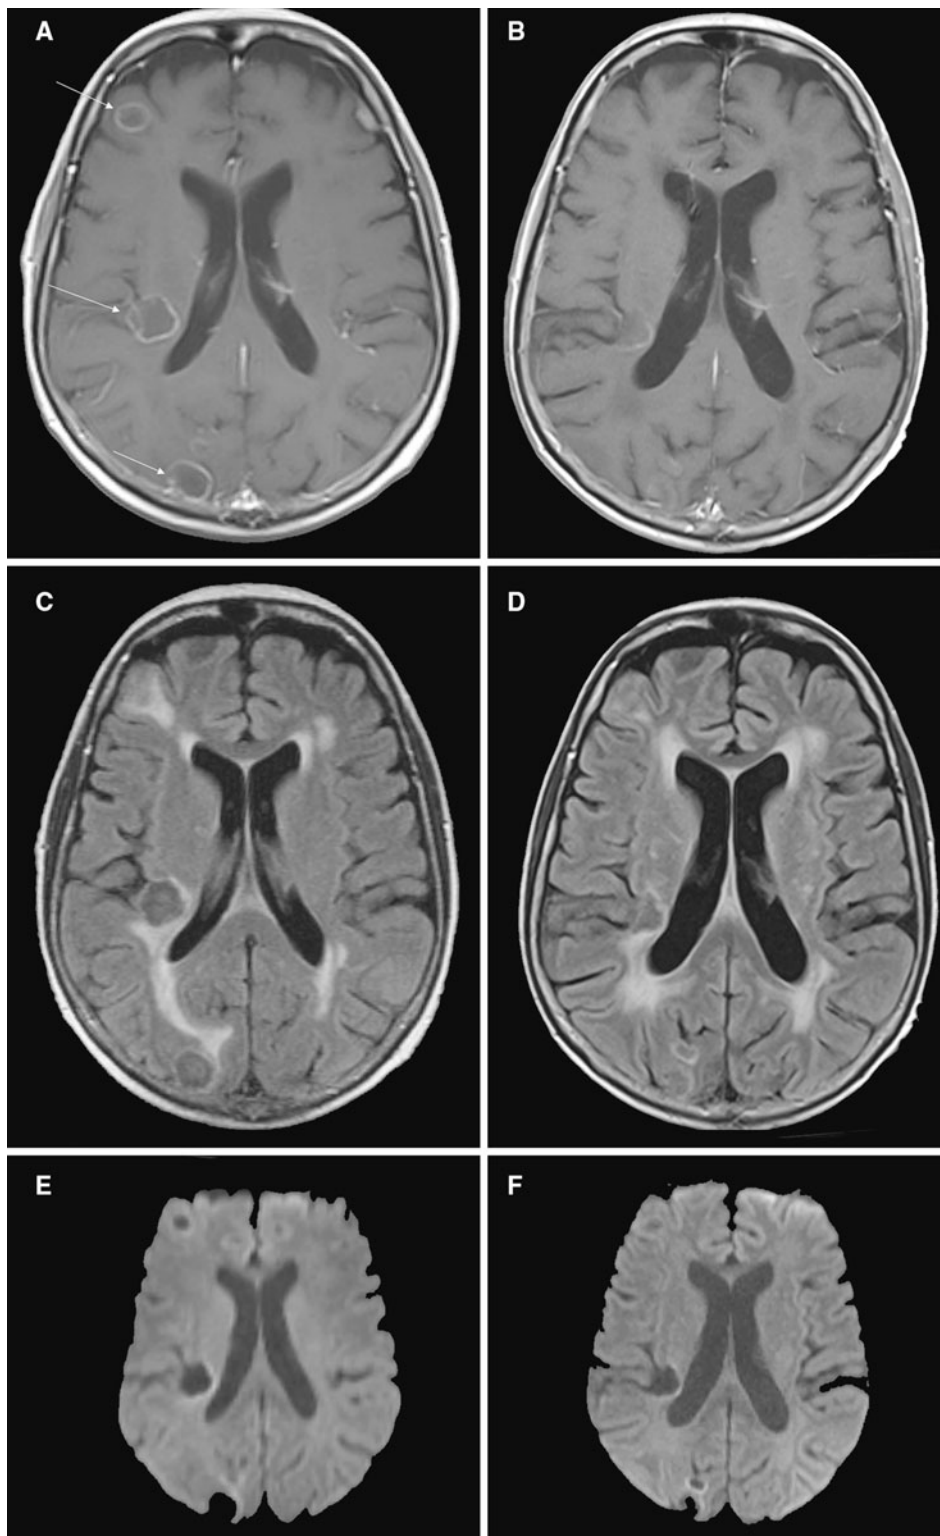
a, c, and e are MR images of the brain prior to treatment with bevacizumab: a T1W post-Gadolinium (Gd) contrast, c T2W Flair, and e DWI b1000. b, d, and f are MR images of the brain after treatment with bevacizumab: b T1W post-Gd contrast, d T2W Flair, and f DWI b1000. On image a the Gd post-contrast T1W, three prominent ring-enhancing lesions (*arrows*) are seen in the right cerebral hemisphere with a large amount of vasogenic edema, which is better seen on image c, the T2W
